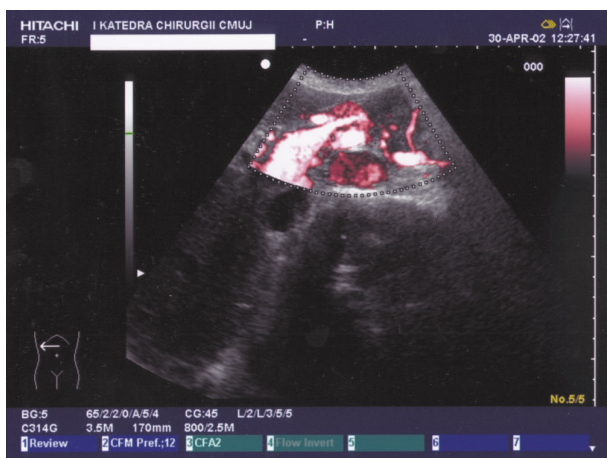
Pancreatic cancer: USG – power-Doppler – infiltration of the portal vein
